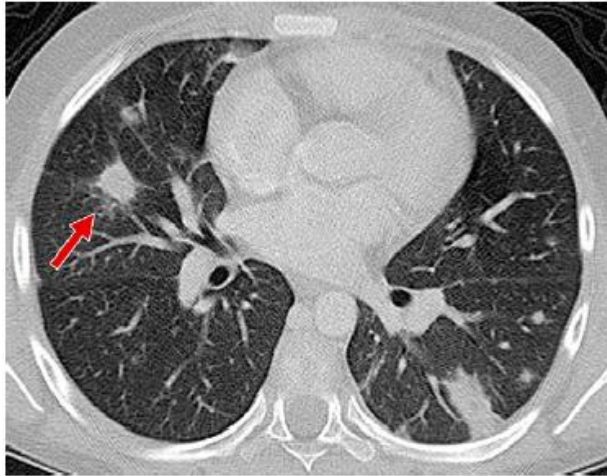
Pneumonia in a febrile neutropenic patient caused by angioinvasive aspergillosis in a 7-year-old boy. Axial contrast-enhanced CT shows multiple bilateral pulmonary nodules, some have rims of ground-glass opacity (*arrow*), which is also known as the CT halo sign.
